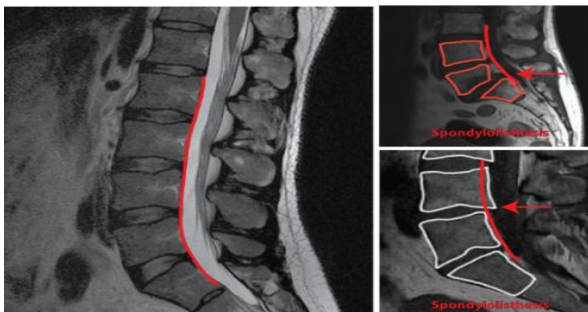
CT, MRI scans of misaligned Lumbar spine
